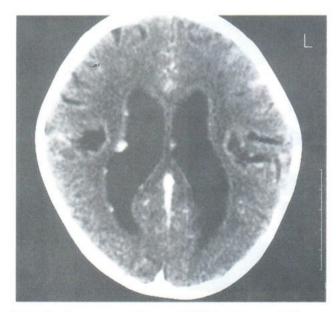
Contrast enhanced CT brain scan shows multiple ependymal nodules seedling with increase enhancement along the venticular wall and leptomeninges linining of the brain (an example of CSF seedling).
